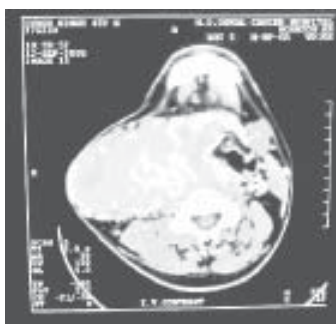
CT scan image of the disease - CT scan neck showed huge mass arising from right lobe of thyroid & measuring 12.6 x 9.5 x 2.3 cm, there was evidence of destruction of right lamina of thyroid & cricoid cartilage, also evidence of destruction of hyoid bone
